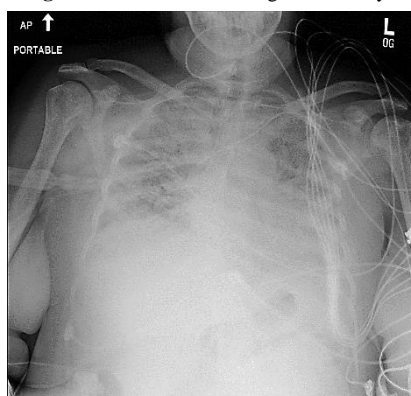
Pleural thickening Chest X-ray
